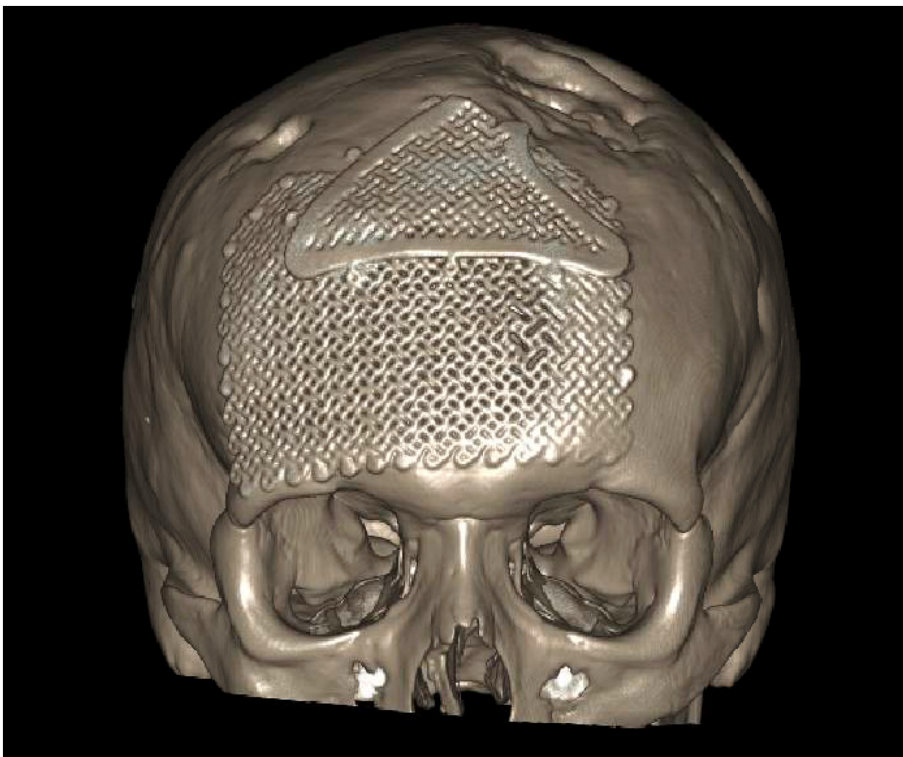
Patient 2-3 dimensional CT scan reconstruction demonstrating titanium implant coverage.
